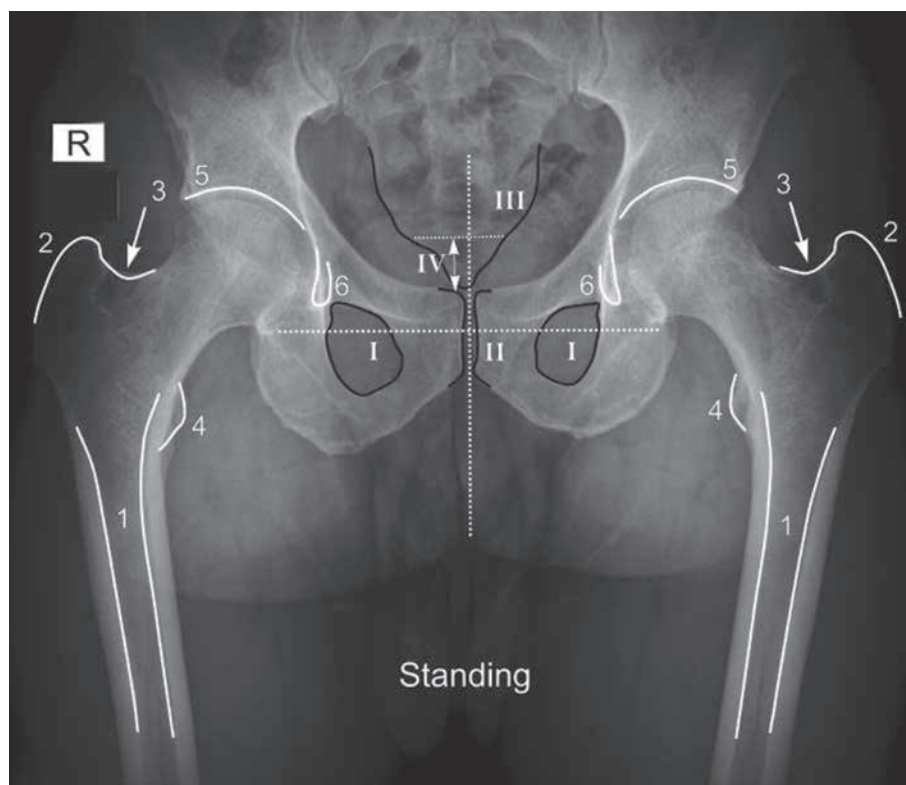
Standing anteroposterior pelvic radiograph suitable for hip templating. Anatomical landmarks : 1. Femoral shaft ; 2. Greater trochanter ; 3. “Saddle” ; 4. Lesser trochanter ; 5. Acetabular roof ; 6. Teardrop. Landmarks for radiographic quality assessment : I. Foramen obturatum ; II. Symphysis ; III. Sacrum ; IV. Distance between symphysis and sacro coccygeal joint. (Scheerlinck T. Primary hip arthroplasty templating on standard radiographs. A stepwise approach. *Acta Orthopaedica Belgica*, Vol 76-4-2010).
